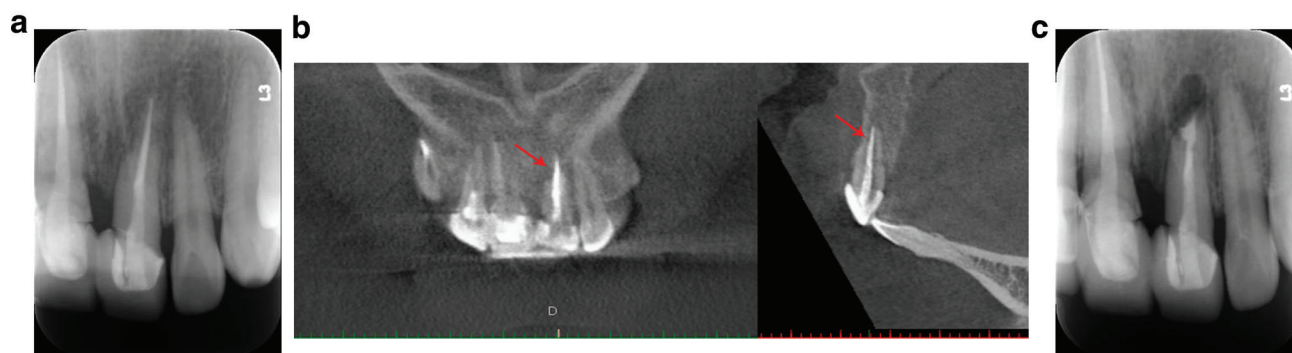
Diagnostic radiograph showing the RRR lesion of tooth 21 (a), CBCT scan showing an RRR lesion image (b), and post-operative radiograph indicating that the lesion was removed and the root-end cavity was adequately filled (c).
